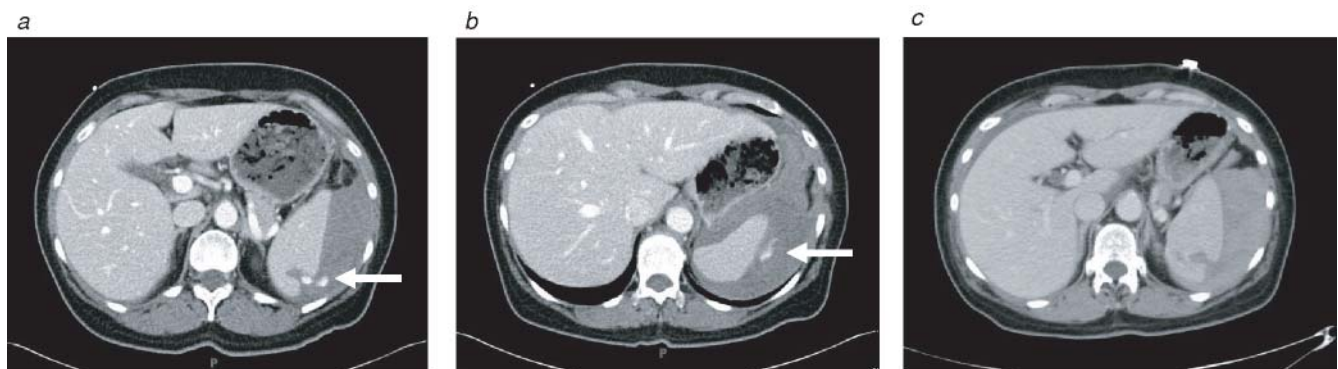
Intraparenchymal splenic blush (arrows) noted on an initial computed tomographic scan (a, b) may resolve following a period of close observation (c).
